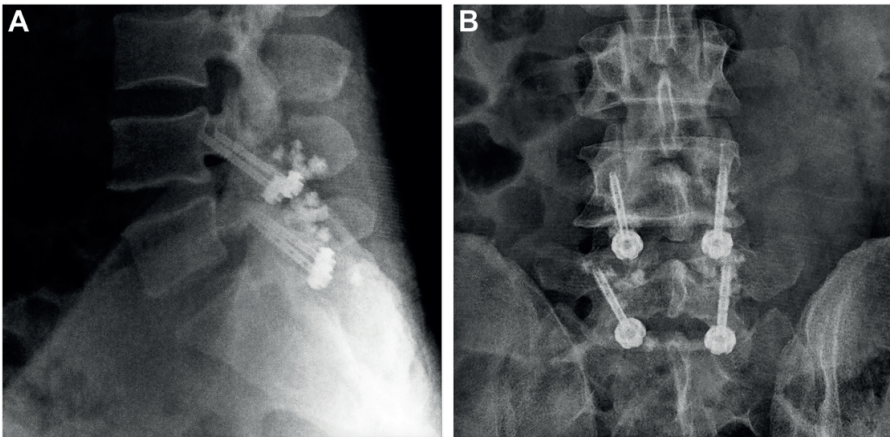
Long-term postoperative radiographs following bilateral percutaneous intralaminar stabilization at L4–L5. (A) Lateral and (B) anteroposterior lumbar spine radiographs obtained during long-term follow-up demonstrating bilateral percutaneous intralaminar screw fixation at the L4–L5 level. The images confirm maintained hardware position and stable posterior element fixation without evidence of implant failure or displacement.
